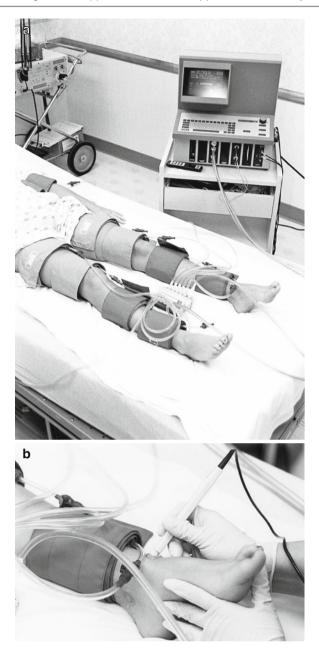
(a) Technique for measuring the segmental Doppler pressures using the four cuff method. (b) The application of the Doppler probe on the dorsalis pedis artery
